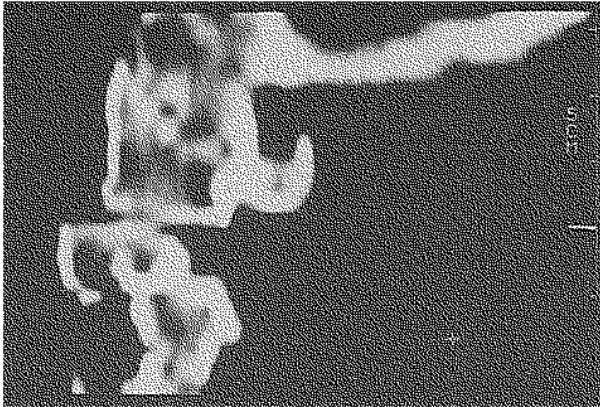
Sagittal CT reconstruction image of the right C1-C2 lateral mass.
